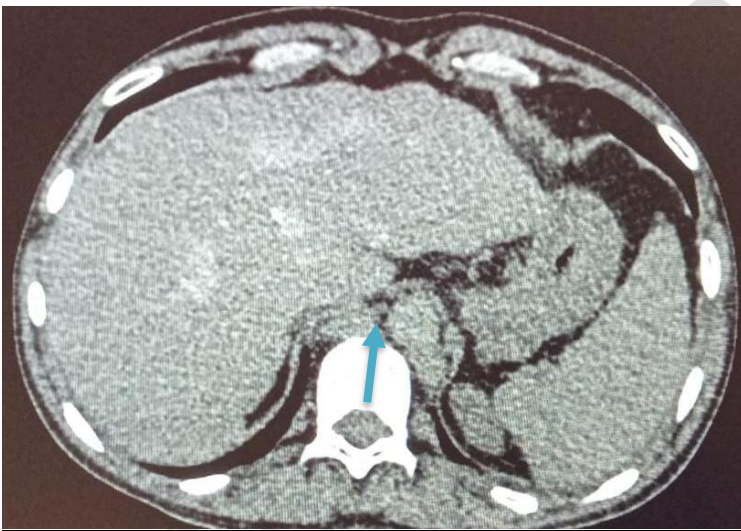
High abdominal axial CT slice demonstrating absence of the middle and lower IVC (→).
